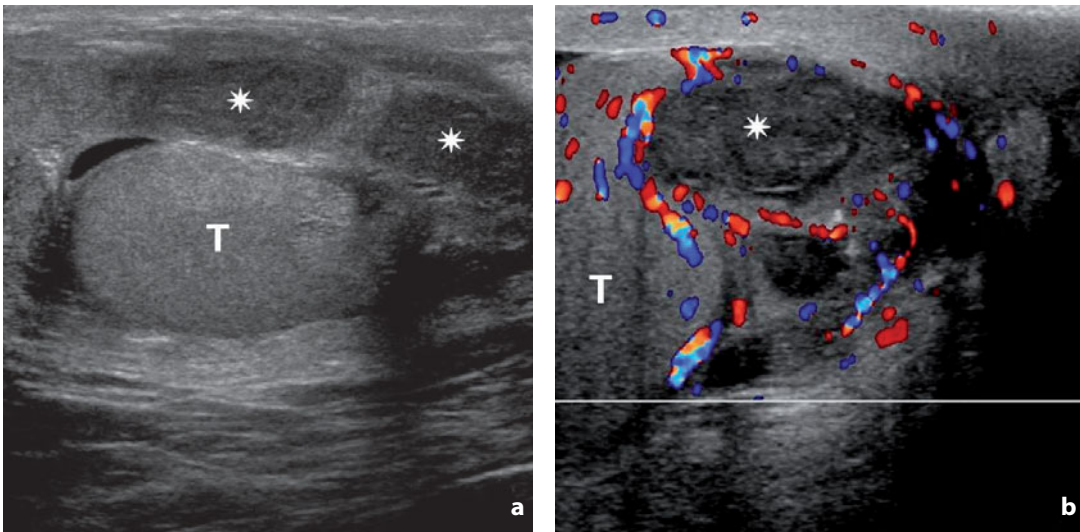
Chronic epididymitis. a Sonogram shows a completely enlarged epididymis (*asterisks*). b A nodular formation (*asterisk*) is visible in the tail, with peripheral hyperemia which compresses the testicle, mimicking a space-occupying lesion. *T*, testicle
